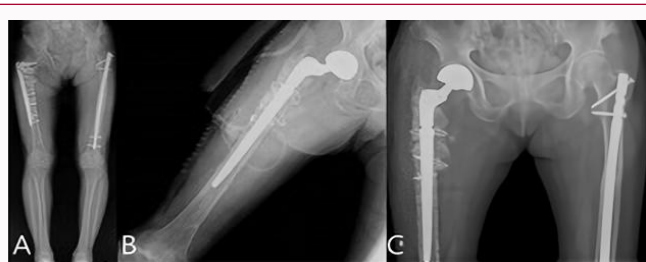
A 74-year-old woman was had intractable non-union of ASF after long term use of bisphosphonate (A). She was treated with bipolar hemiarthroplasty (B). At 6 months after the arthroplasty, she had no pain and could ambulate with walker. The stem was well fixed on radiograph (C).
